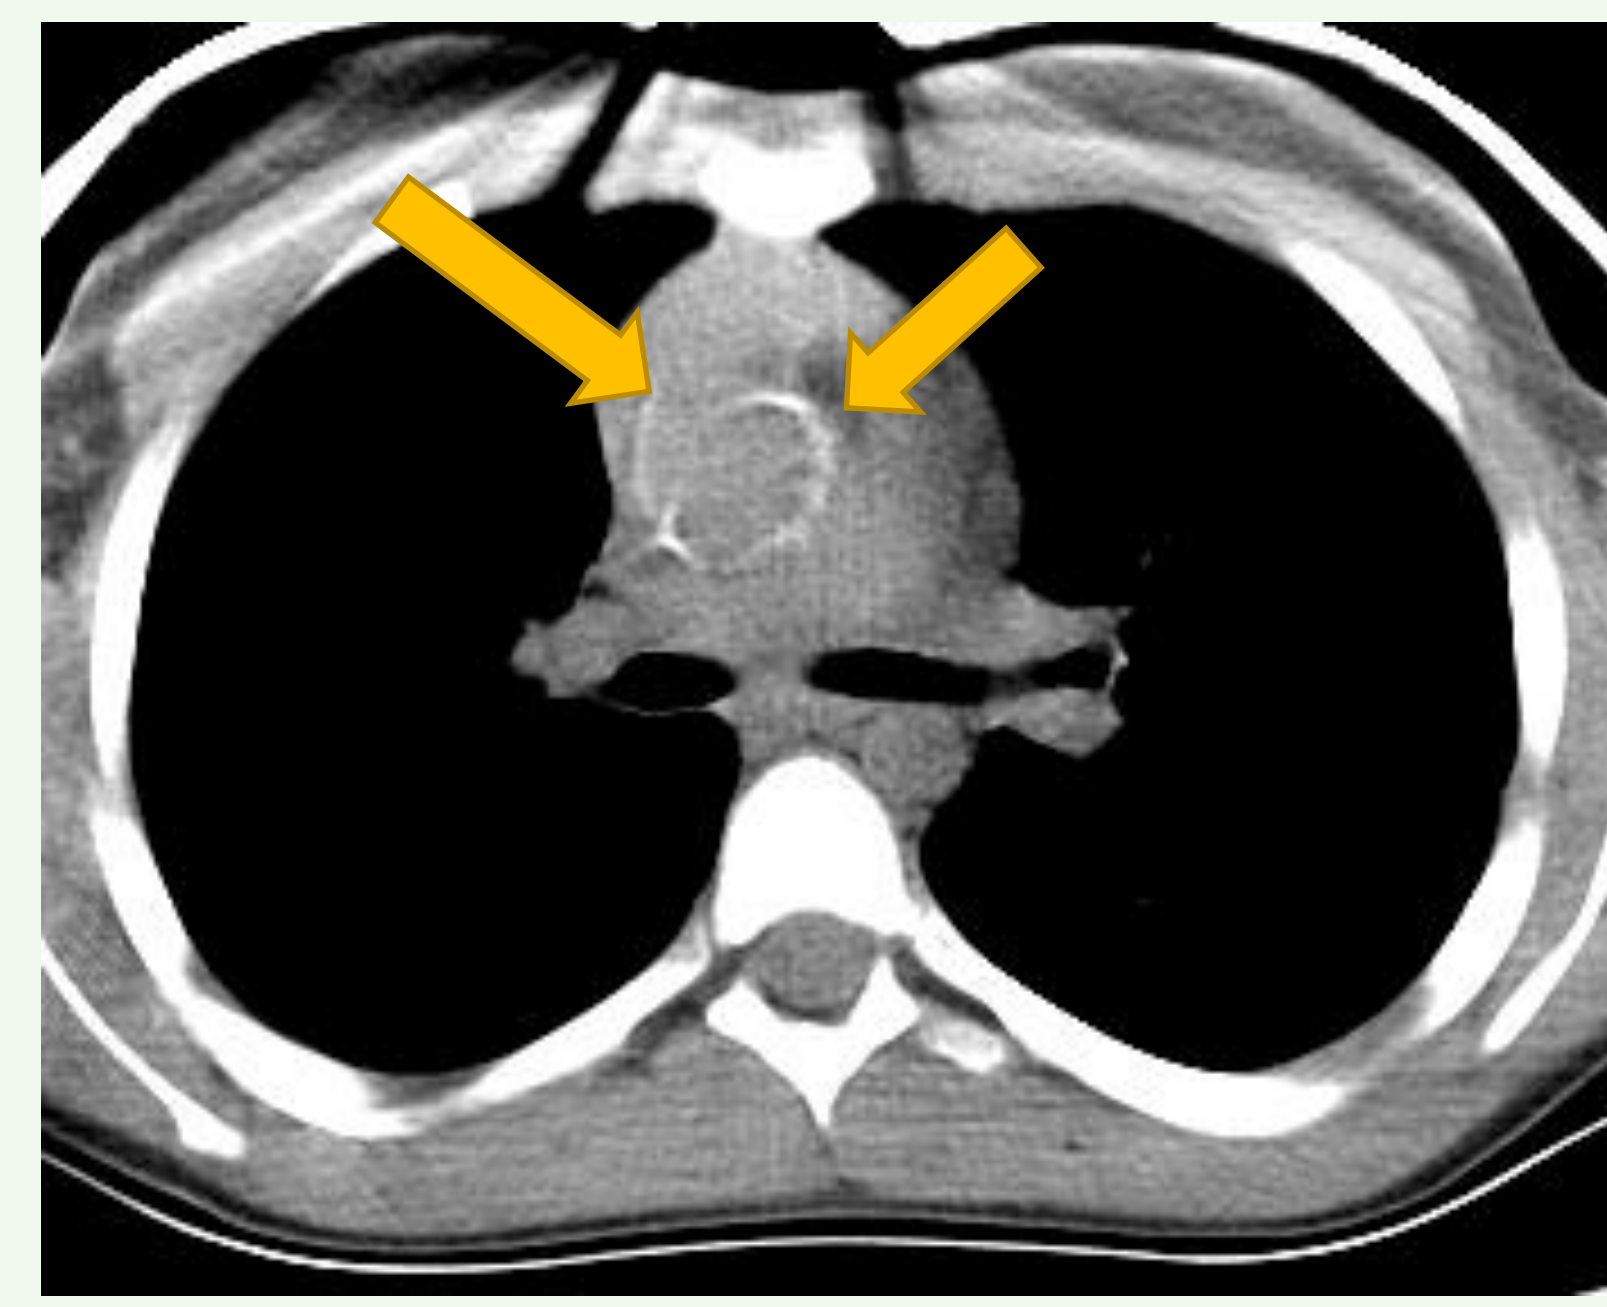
At 12 years, cardiac CT demonstrates significant intimal calcification of the aortic arch and coronary arteries.
